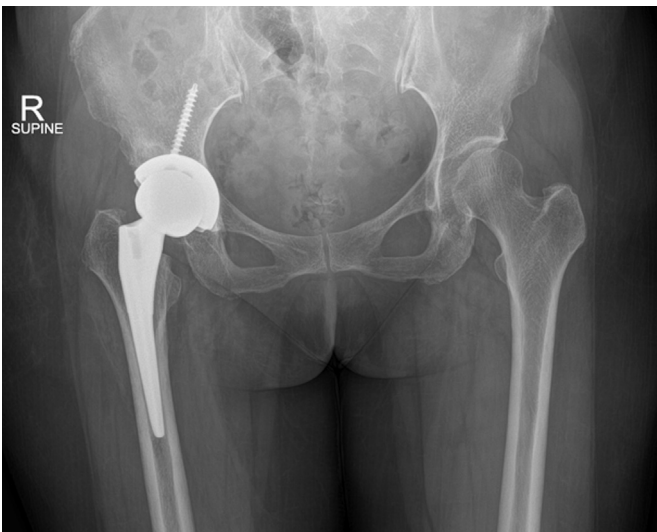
Postoperative radiograph of the patient, both hip AP.
